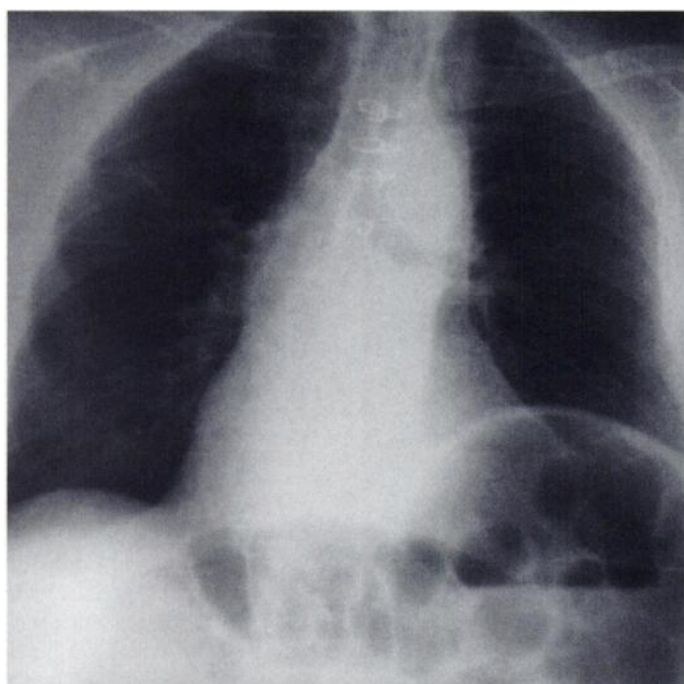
Posterior-anterior chest radiograph obtained 6 wk after antibiotic therapy shows near-total resolution of right upper lung consolidation area.
